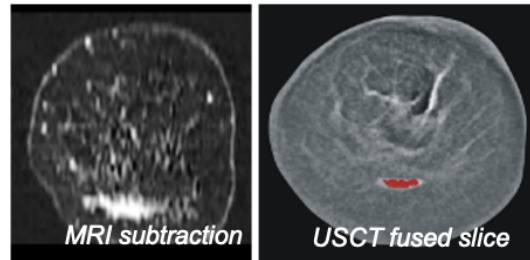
Example of an USCT fused information: On the left side, the MRI subtraction image indicates the position of the cancer. The right image shows a reflectivity slice approximately at the same position with overlaid region of high speed of sound for this patient.
